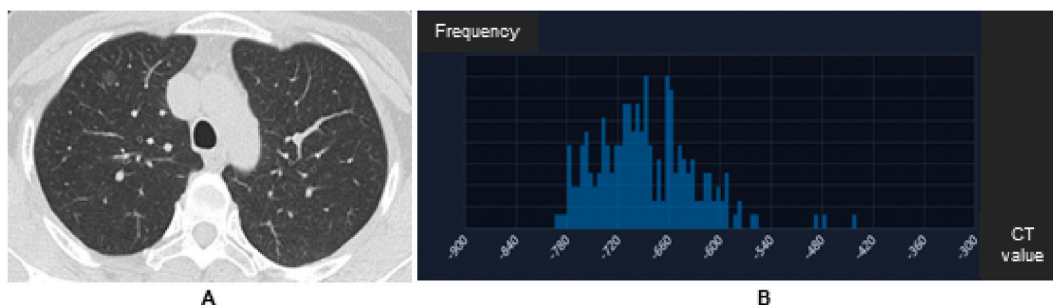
A 51-year-old woman with atypical adenomatous hyperplasia (AAH) in the right upper lobe. (a) A transverse thin-section CT (1 mm thickness) scan shows a pure ground glass nodules (pGGN) (arrow) with a major diameter of 8 mm, a well-defined, smooth interface and a mean CT value of -697 HU. (b) The three-dimensional (3D) CT values histogram of the pGGN was calculated using artificial intelligence (AI) automated image analysis tool.
